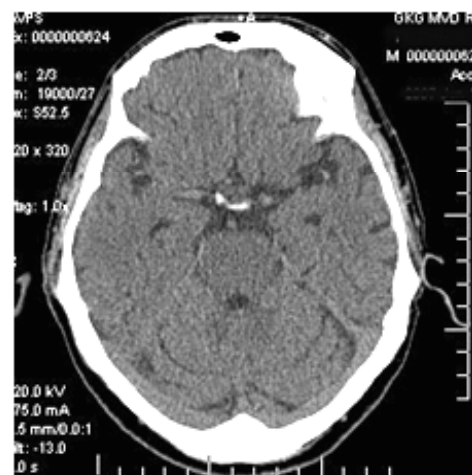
Same patient T., 66 years old, 5 years after transcatheter intracerebral laser exposure. Brain CT.
